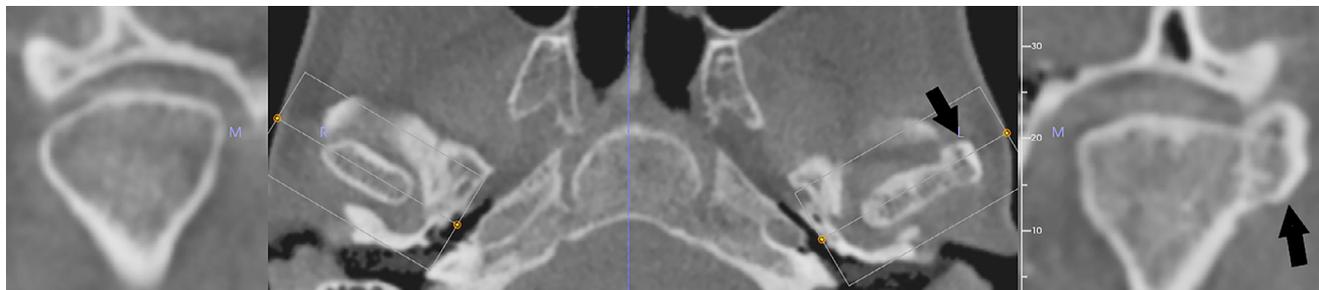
Coronal and axial CBCT of a cancellous osteoma shows a well-defined pedunculated mass attached to the lateral pole of the condyle. It has a thick cortical outline and the internal surface shows trabecular patterns similar to the native condyle. The differential diagnosis includes an osteochondroma.
